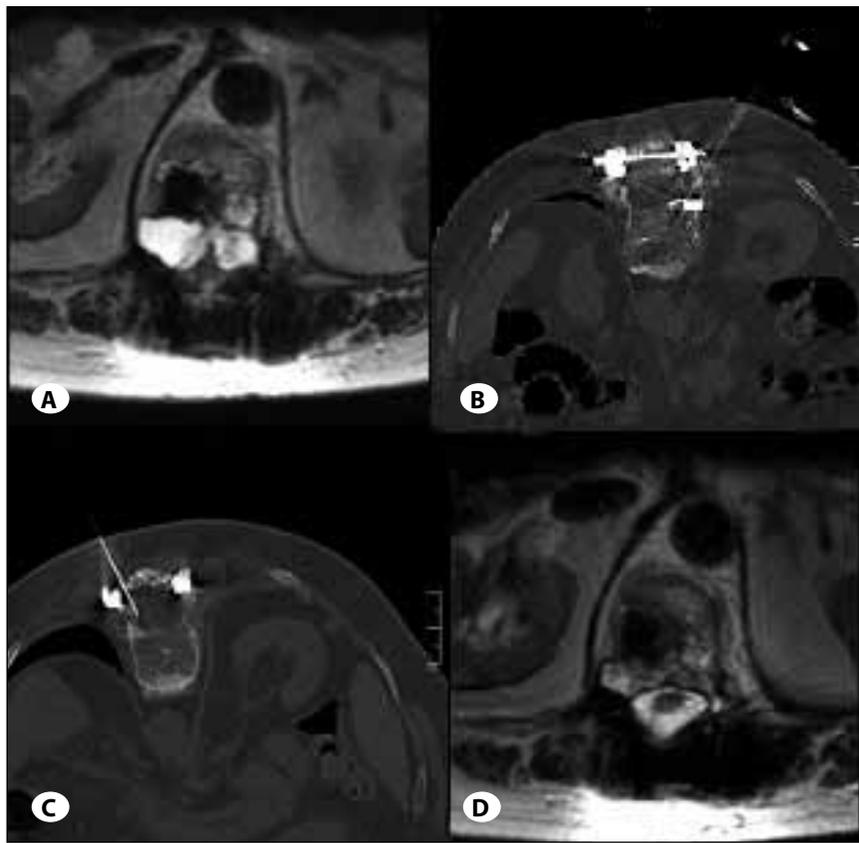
A) Axial T2-weighted MR image shows two cystic lesion located on corpus of T12 vertebra posteriorly and spinal cord compression. B) Axial CT image during intervention. A 19 G needle placed into the cysts through the right pedicle. Note there is no communication with the thecal sac. C) Axial CT image of the 19 G needle placed into the cysts through the left pedicle. D) The control axial T2-weighted MR image shows marked reduction in cyst volumes and disappearance of cord compression.
